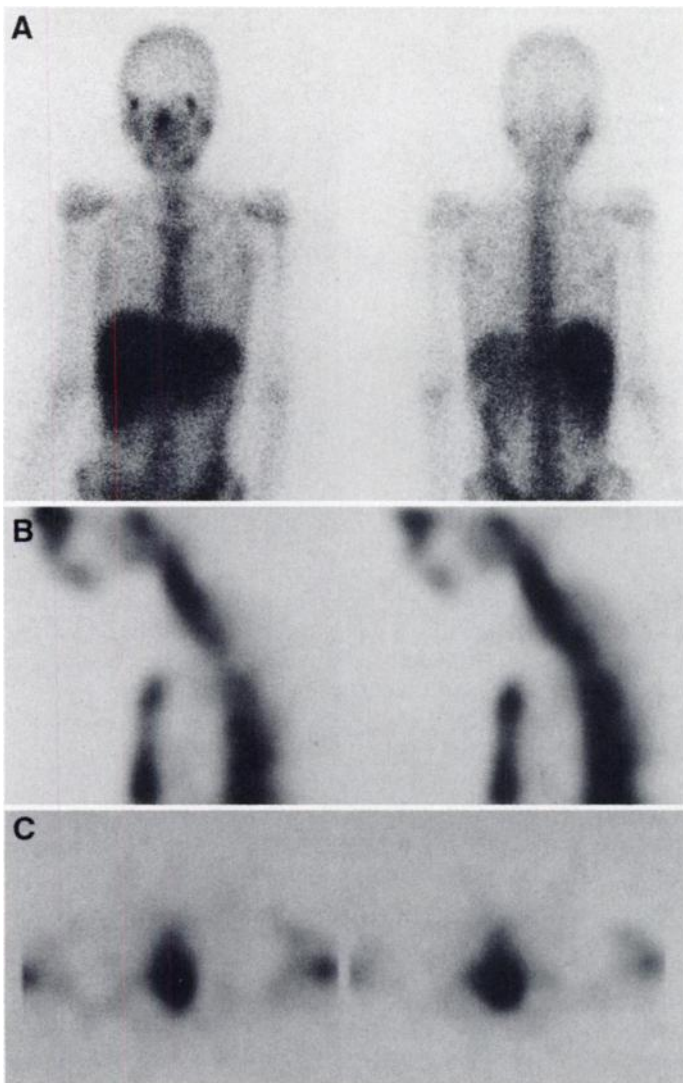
(A) Gallium scintigrams before steroid treatment demonstrate intense uptake in the medial neck and bilateral chest wall. On sagittal (B) and axial (C) SPECT images of neck, arrows show abnormal uptake anterior to the vertebral body.
